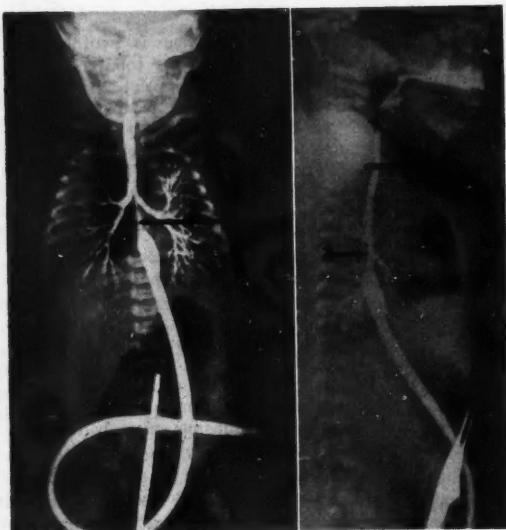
Case 2.—The post-mortem roentgenographic findings are demonstrated. The upper (1) and lower (2) esophageal segments are indicated. See text. The soft tissue density of the arms partially obscures the upper segment in the lateral view.
